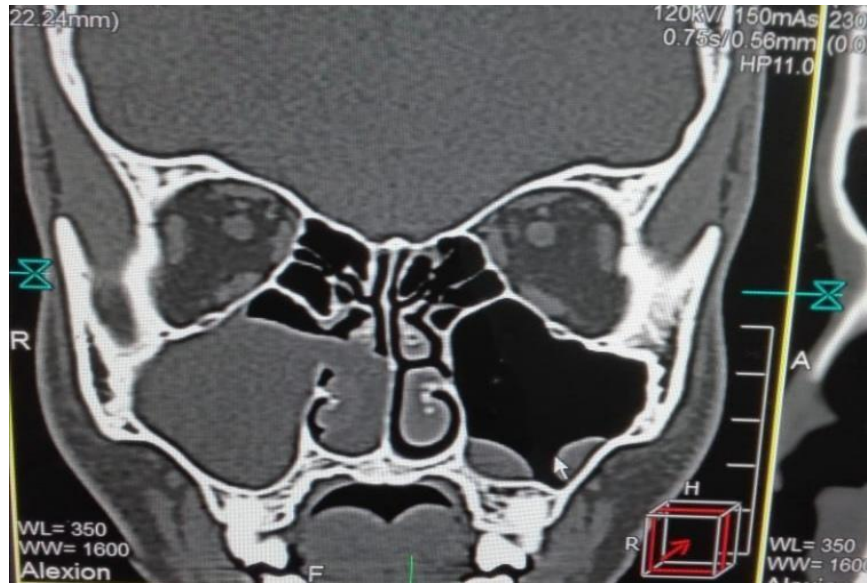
shows 30 years old female coronal CT with polyp in rt and lt maxillary and rt ethmoid
